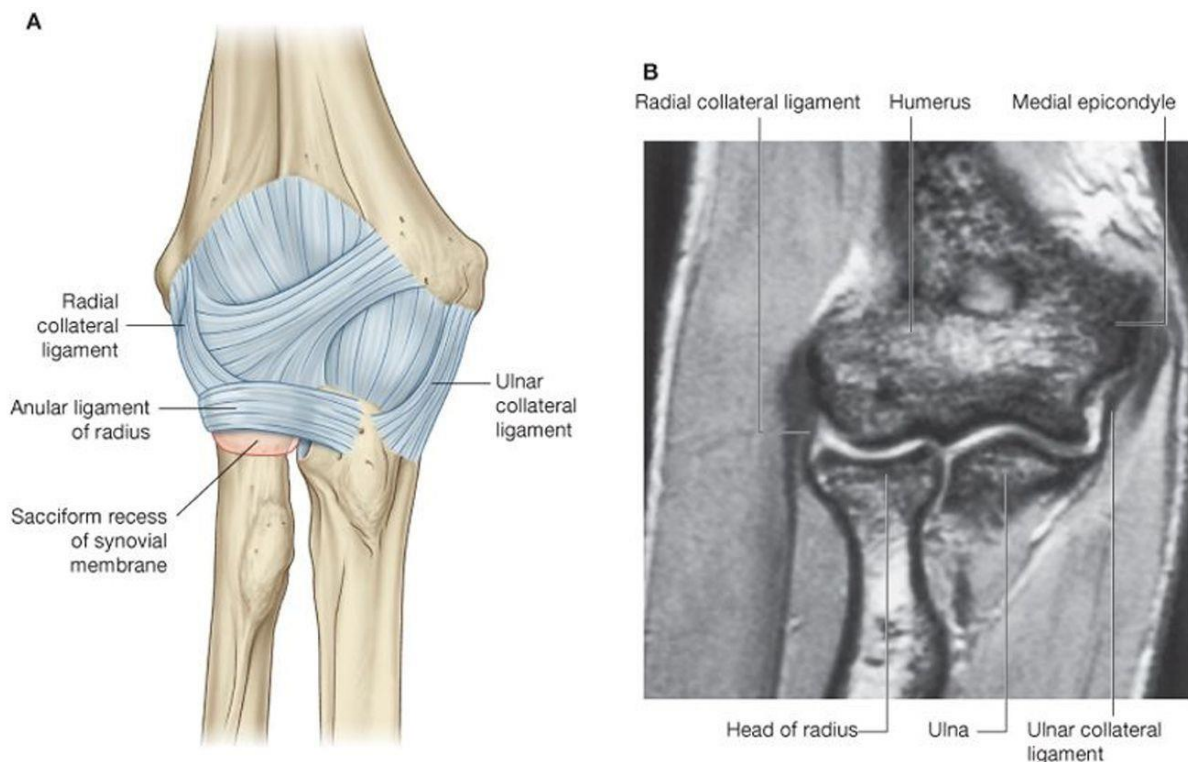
Elbow joint. A. Joint capsule and ligaments of right elbow joint. B. Magnetic resonance image of elbow joint in coronal plane. Gray's Anatomy for Students.¹⁷
